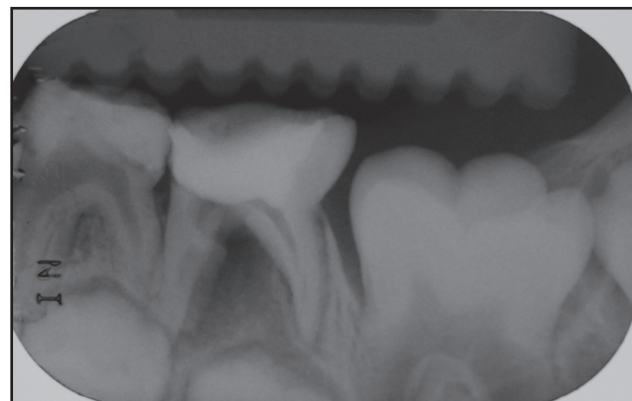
Preoperative radiograph showing the presence of pulpotomy and evidence of a circumscribed radiolucent lesion associated with the furcation area.
